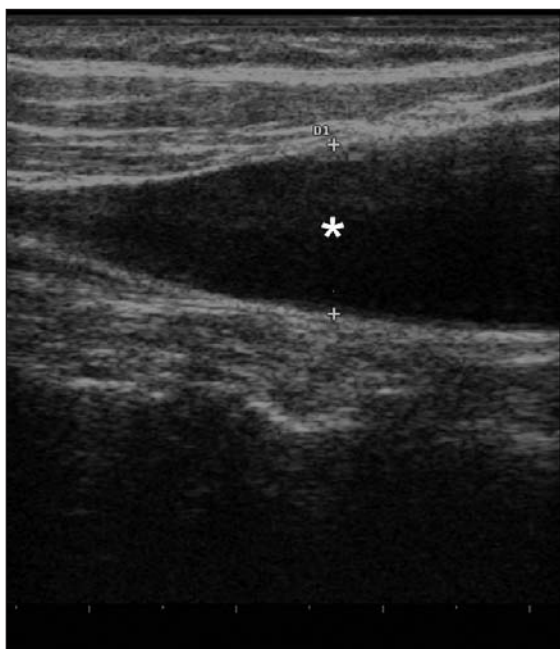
Ultrasonography image showing a longitudinal view of the internal jugular vein with the probe indicator pointed toward the patient's head. The asterisk marks the beginning of the taper. Used with permission from The EDE 2 Course Inc.
